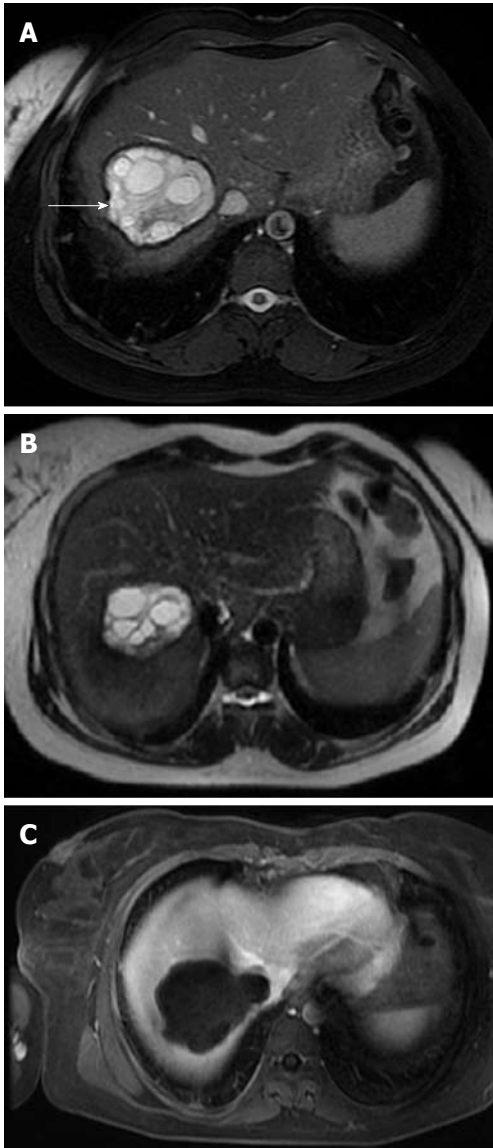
Axial T1-weighted (A) and T2-weighted (B) images show a well defined cystic lesion and the typical peripheral location of the daughter cysts within the mother cyst. Note the marked hypointensity of the pericyst (the white arrow). After contrast administration (C) the cystic lesion does not show contrast enhancement (type II).
